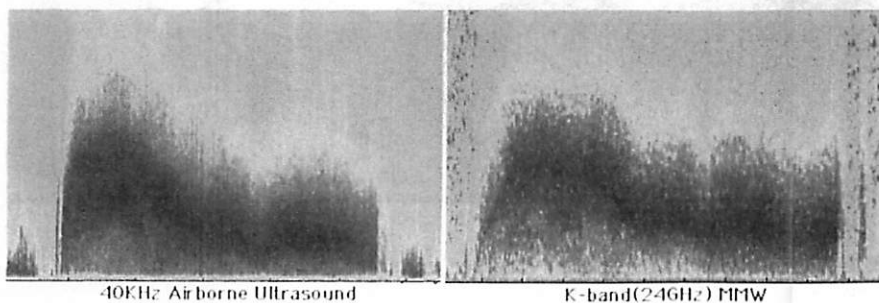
Scale factor matched presentation of Doppler spectrums of typical urination, 40KHz airborne ultrasound (left) and K-band microwave (right). Horizontal axis span is 30 second.
